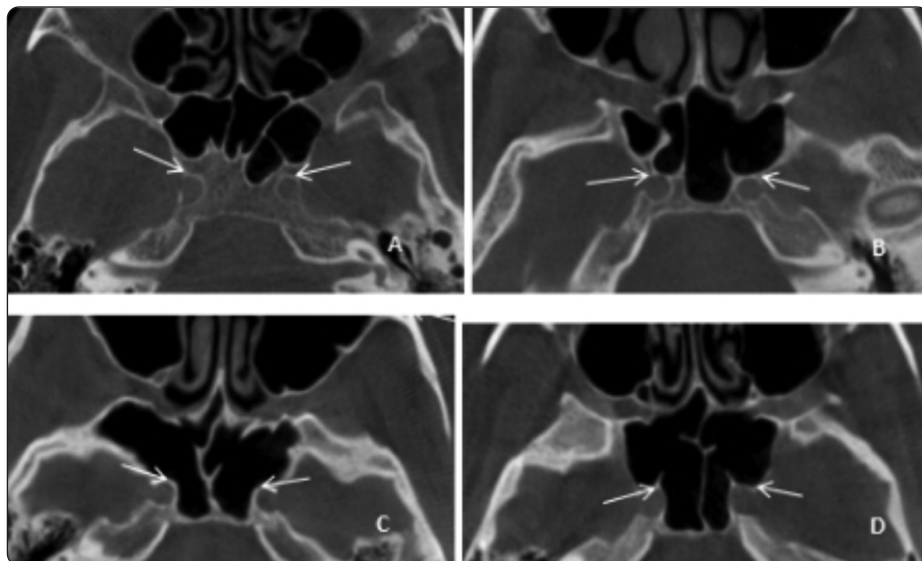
Axial cuts of CBCT showing relation of sphenoid sinus to ICA : A: grade 0, B: grade 1, C: grade 2 and D: grade 3.
